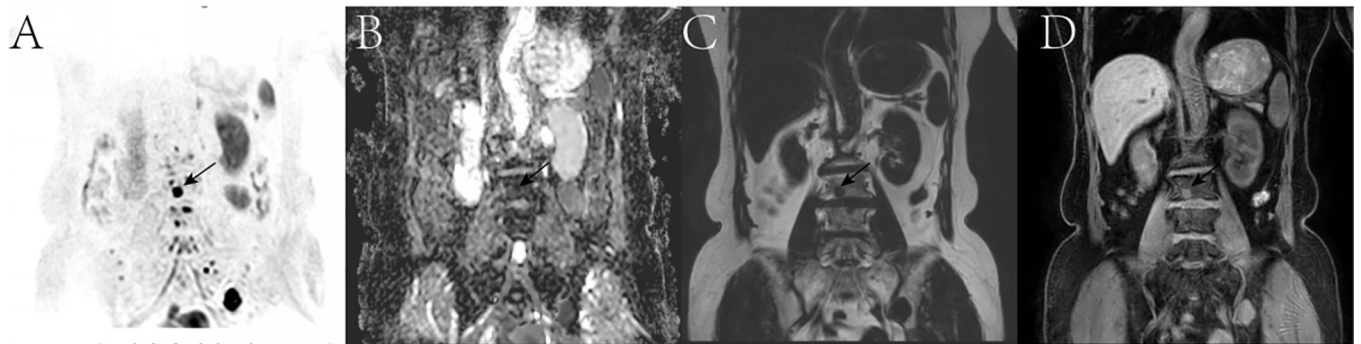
(A,B,C,D) The DWI, ADC, fat phase, and water phase images are displayed respectively. No artifacts were seen and the lesions were clearly shown (arrows). DWI, diffusion-weighted imaging; ADC, apparent diffusion coefficient.
